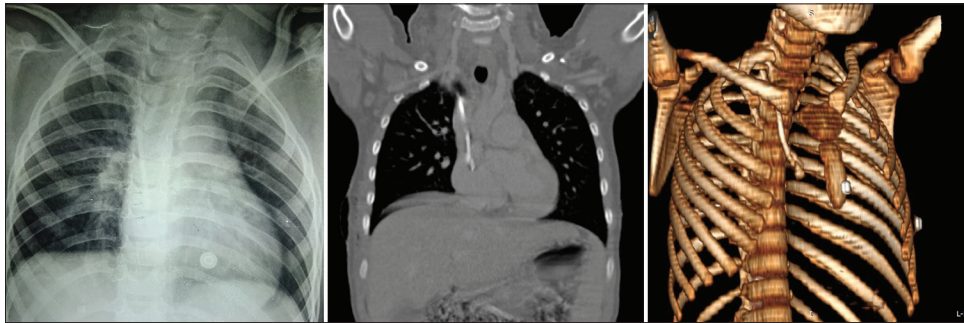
Chest radiograph showing the fractured distal end of the chemoport. Coronal computed tomography chest image confirming the radiograph finding. Three-dimensional reconstructed Volume Rendering Technique (VRT) image of the thorax showing the fractured piece
